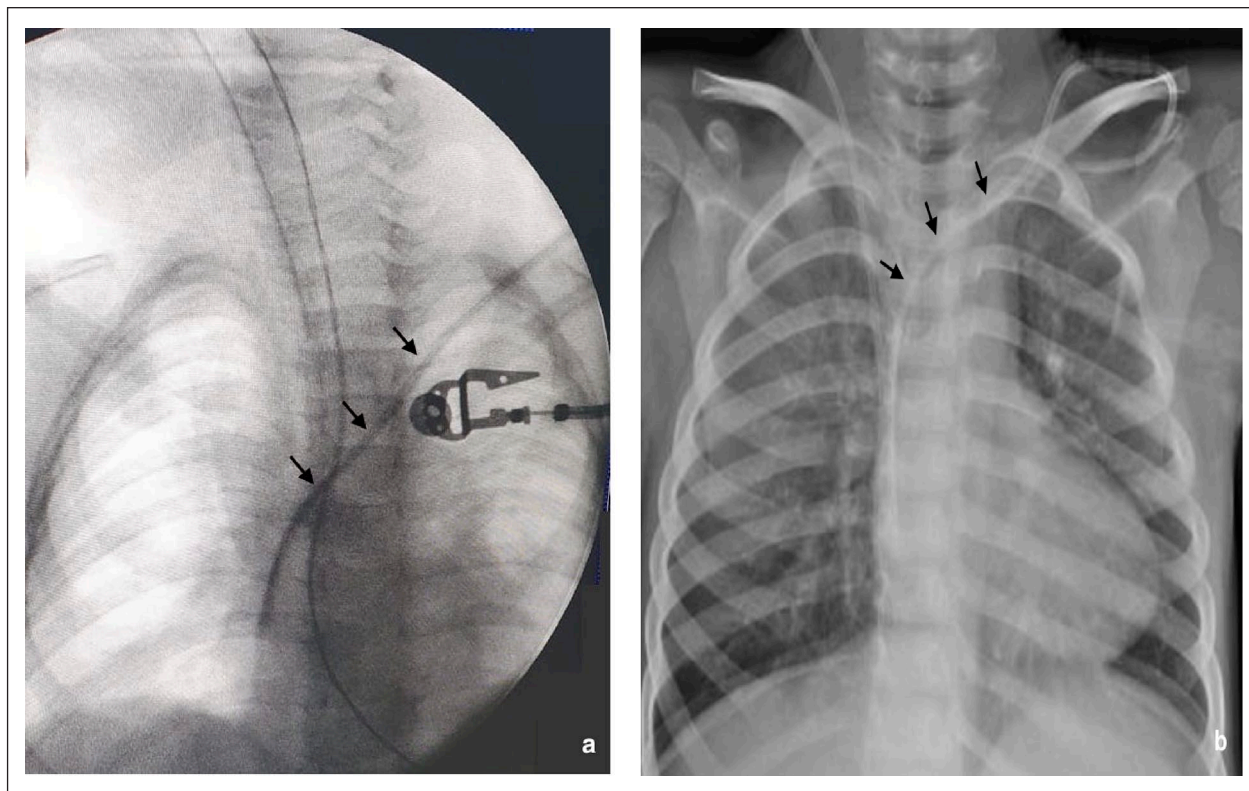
(a) Fluoroscopic image of the patient of the case report. Arrows are indicating a vertical/oblique catheter path in the subaortic left brachiocephalic vein. (b) X-ray of a patient of the same age (12 months old) as the case report patient. Arrows are indicating a normal catheter path in the left brachiocephalic vein above the aorta.
